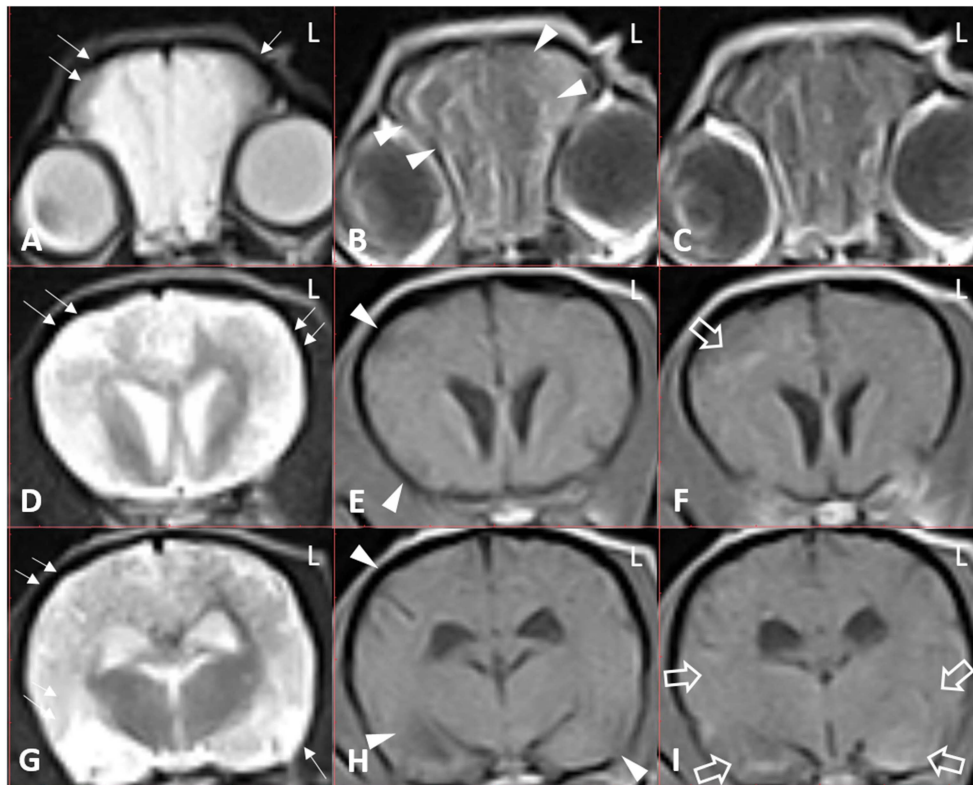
MRI findings at 91 days after initial presentation. A, D, G: Transverse T2-weighted images. B, E, H: Transverse T1-weighted images. C, F, I: Transverse post contrast T1-weighted images. Markedly hyperintense diffuse lesions (arrows) were seen on T2-weighted images, and these lesions showed loss of demarcation between the gray and white matter. The lesions produced hypointense signals (arrowheads) on T1-weighted images and were irregularly enhanced (empty arrows) following administration of contrast medium.
